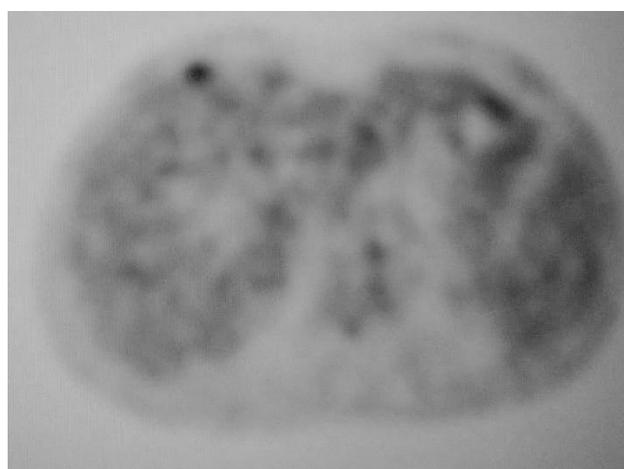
Liver metastatic deposit in segment VIII in the right lobe of liver on FDG-PET.
